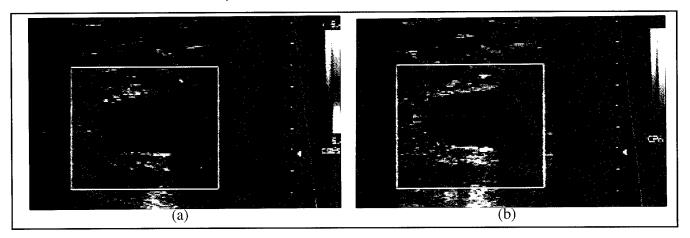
Doppler images of a patient with benign tumor: (a) color Doppler image, (b) power Doppler image.
